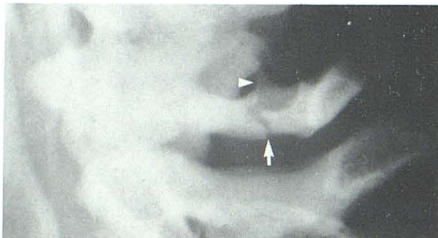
Case 1. One of four similar lateral cervical spine radiographs, each showing fracture through one side of posterior arch of atlas (*arrow*) and absence of fracture through other side, with unilateral ponticulus posticus intact (*arrowhead*).
